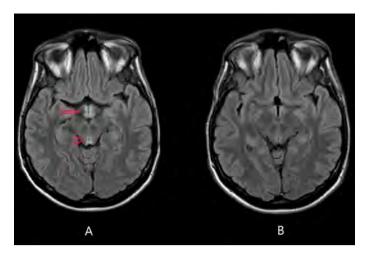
A) FLAIR weighted axial MRI images showed bilateral and symmetric hyperintensity at fornices and mammillary bodies (red arrowhead) and periaqueductal gray (red arrow); the same signal features were present also in the postero-medial portion of both thalami (not showed in the Figure); B) Image B: after 45 days of treatment brain MRI scan showed normal signal in those areas.
